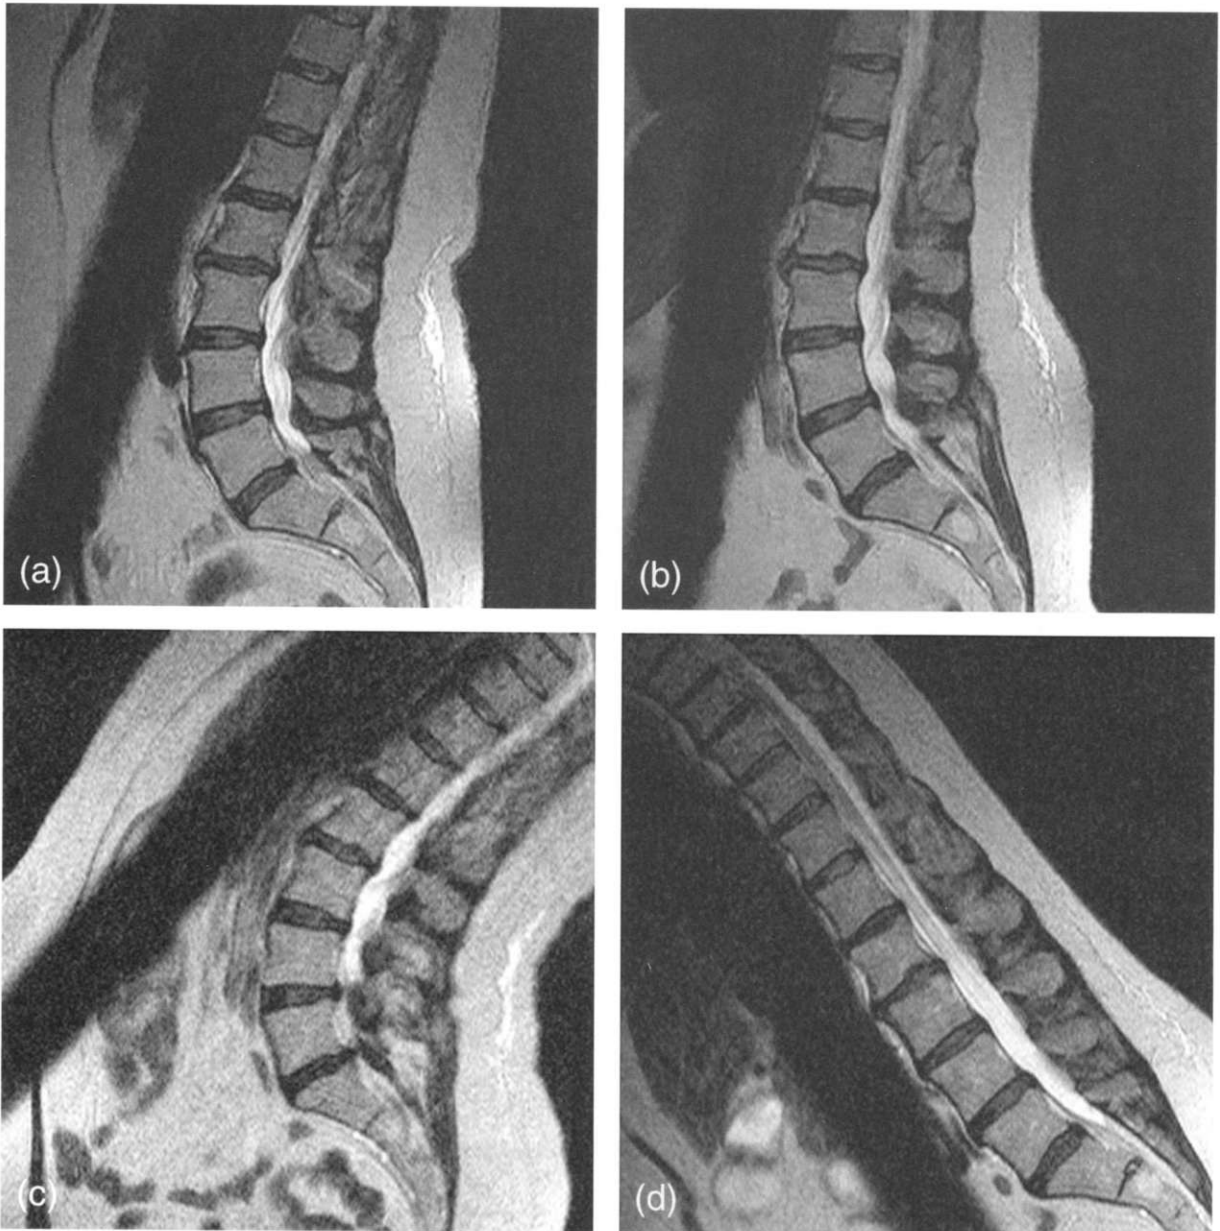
Worsening-reducing spinal stenosis. (a) Recumbent midline sagittal T2-weighted fast-spin echo MRI (rMRI) shows mild, generalized spondylosis and minor narrowing of the central spinal canal inferiorly. (b) Upright-neutral midline sagittal T2-weighted fast-spin echo MRI (pMRI) shows mild worsening of the central spinal canal stenosis inferiorly. Note the assumption by the patient of the true postural sagittal curvature of the lumbosacral spine as compared to the recumbent examination. (c) Upright-extension midline sagittal T2-weighted fast-spin echo MRI (kMRI) reveals severe worsening of the central spinal canal in the lower lumbar area (L4-L5, L5/S1). (d) Upright-flexion midline sagittal T2-weighted fast-spin echo MRI (kMRI) demonstrates complete reduction of the central spinal canal stenosis at every lumbar level.
